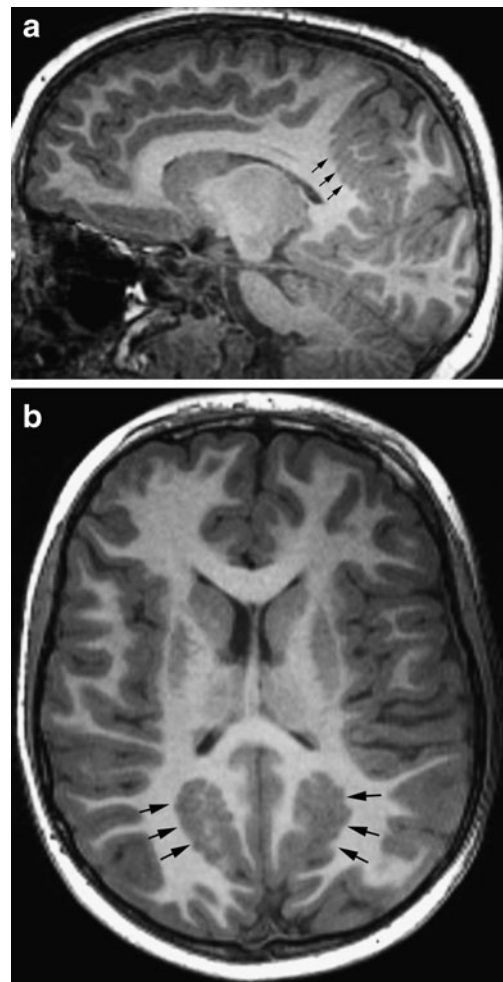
Bilateral parasagittal parieto-occipital polymicrogyria. Parasagittal (a) and axial (b) T1-weighted images show coarse parasagittal infoldings (arrows) of polymicrogyria
